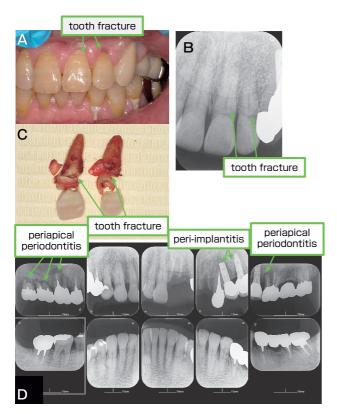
Dental photography and X-rays. Dental photograph before the extraction of fractured teeth, (B) dental X-ray photo, (C) extracted fractured teeth, and (D) full mouth dental X-ray photos after the extraction of fractured teeth. *Green arrows*: Tooth fracture lines (A-C), periapical periodontitis, and peri-implantitis (D).
